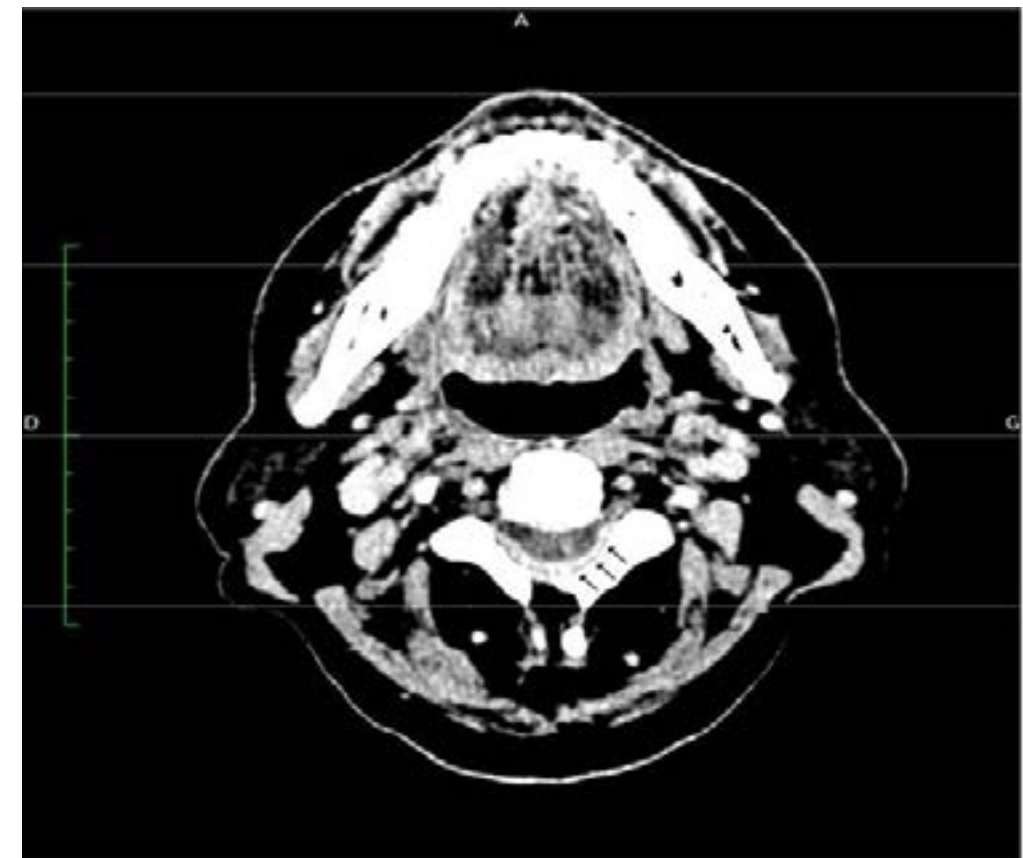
CT-scan axial image showing thickening of the meninges between the C1–C2 vertebrae.
